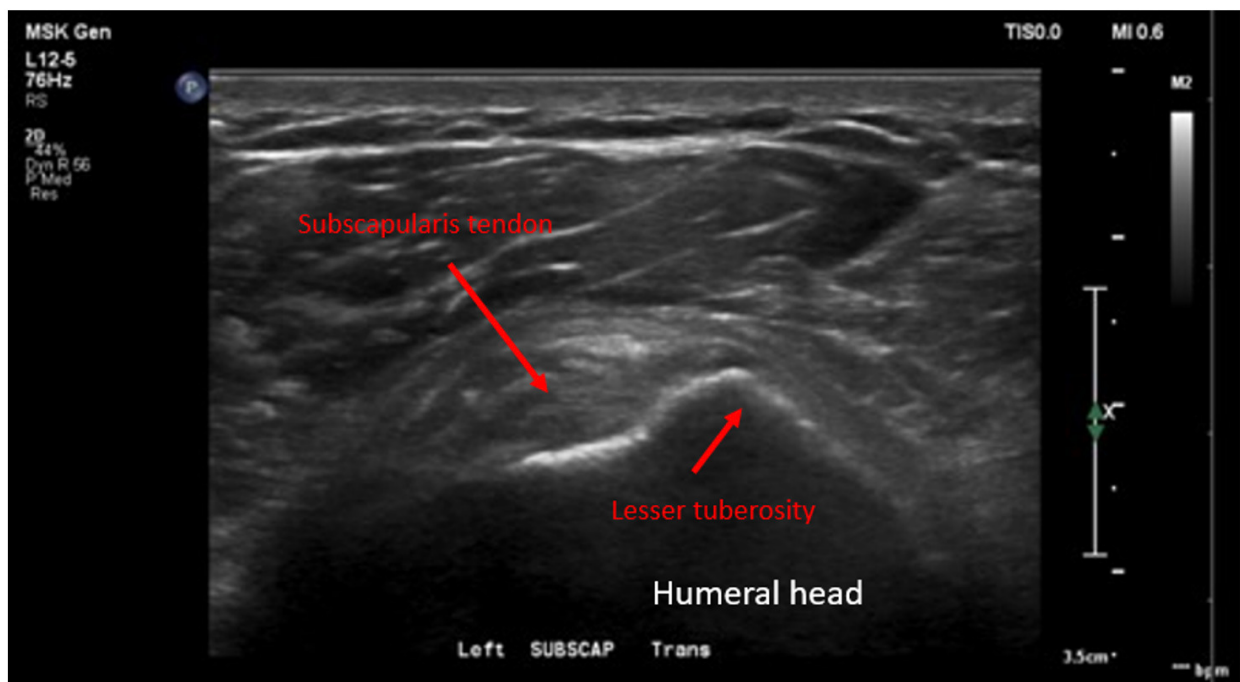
Patient #3 representative 6-month post-operative ultrasound showing an intact subscapularis tendon with mild tendinosis.
